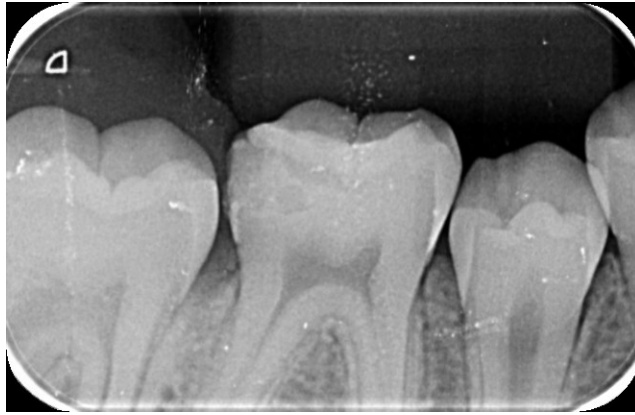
Periapical radiography 8 months after excision of the lesion
